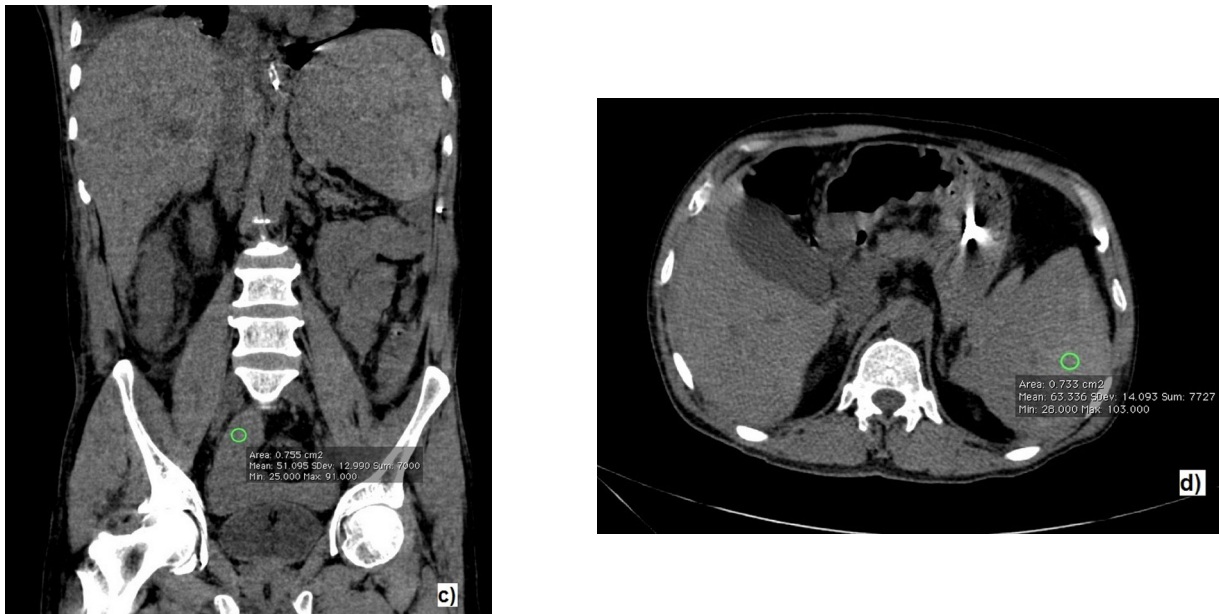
a - Ultrasound abdomen showing a large heterogeneous layered appearance along the superior aspect of spleen (open white arrow) suggestive of splenic rupture with hematoma formation. Part of normal spleen is also seen (open black arrow), 2b, c & d - Non-contrast computed tomography scan also revealed multiple hyperdense (HU 60-70) and hypodense region along the diaphragmatic surface of spleen suggestive of a large perisplenic hematoma and hemoperitoneum.
